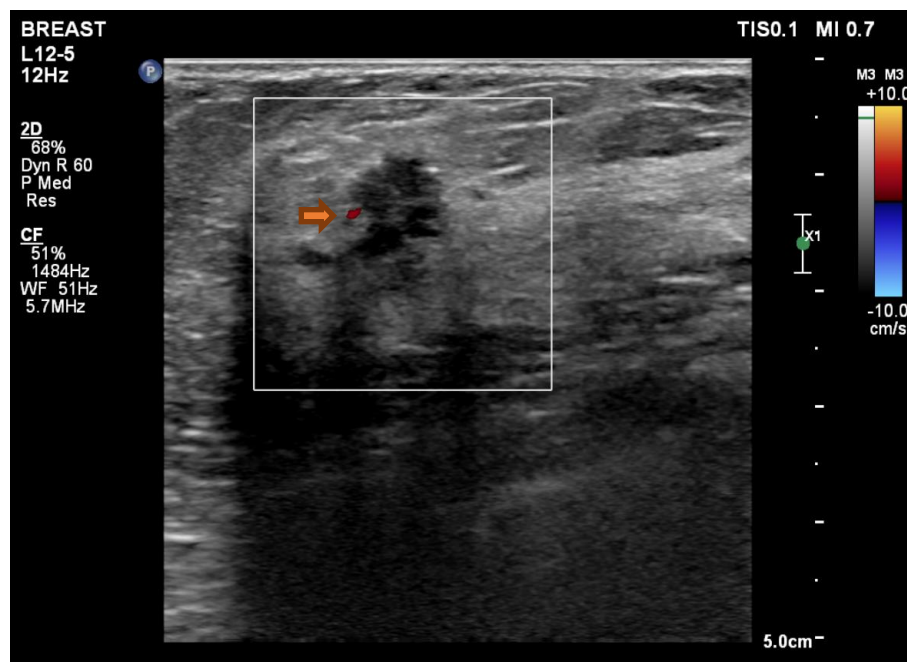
D: On Doppler interrogation reduced internal vascularity noted with 1 flow signal (➡
